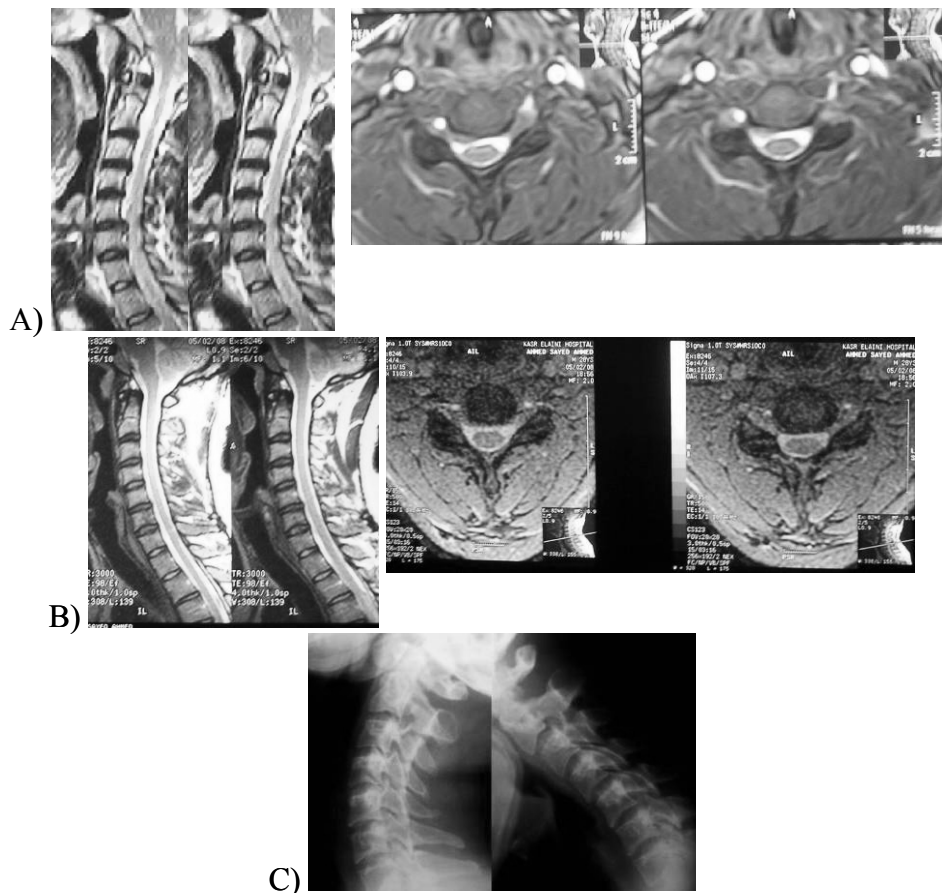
A) preoperative MRI reveals C5-6 lateral disc. B) postoperative MRI reveals free root at C5-6. C) postoperative dynamic x-rays shows intact stability
